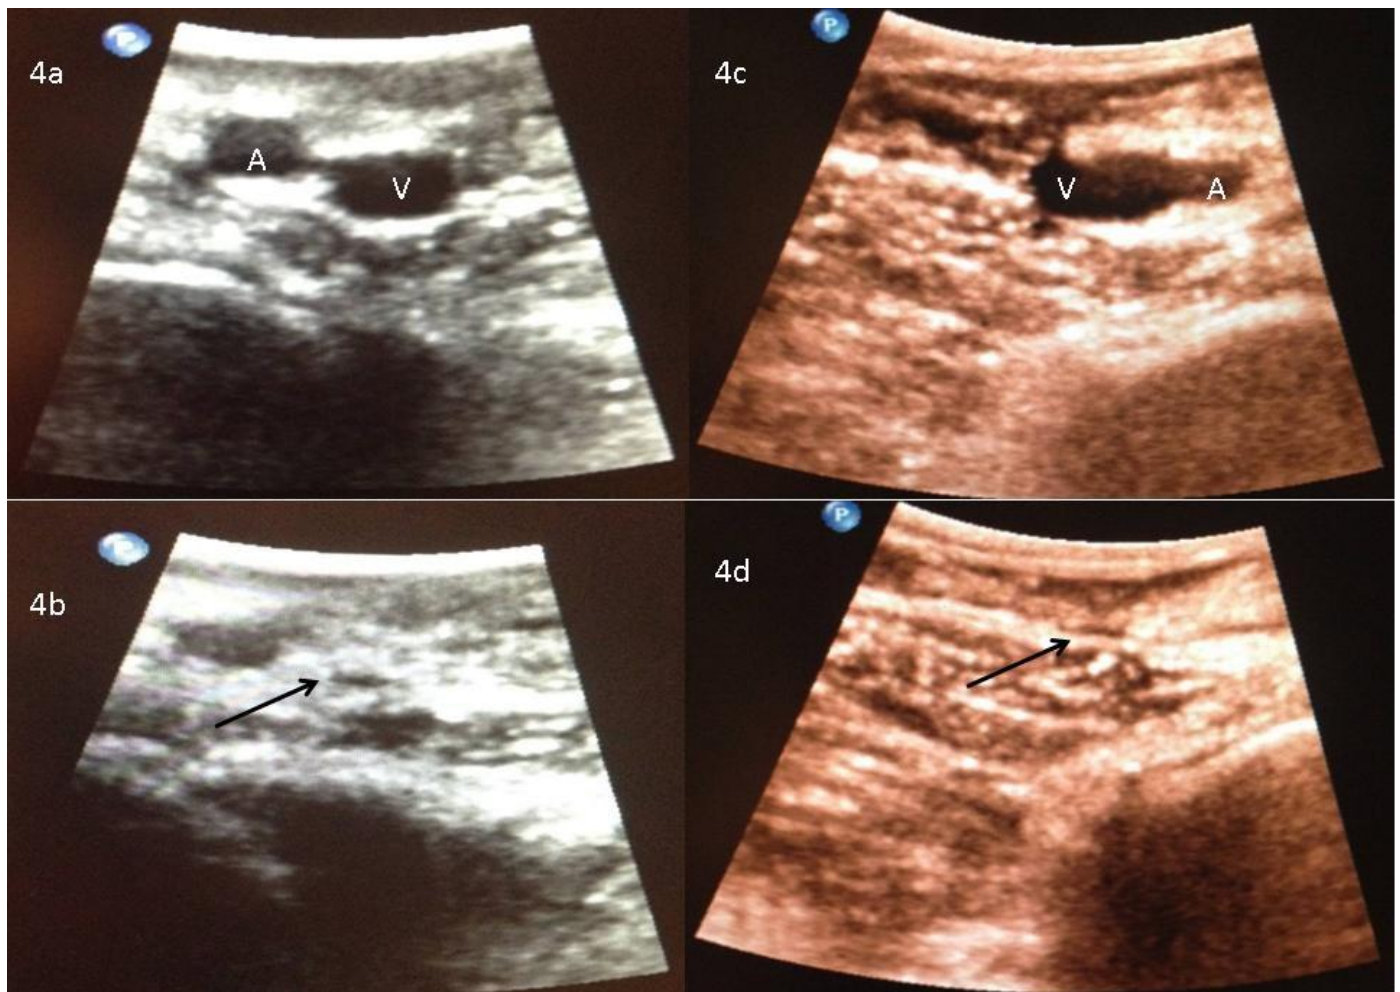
53-year-old female with a large leiomyoma with extension into the right gonadal vein and inferior vena cava. Findings: Transverse and longitudinal sonographic images of the bilateral lower extremities. 4a) Right common femoral artery (a) and vein (v) which appear patent without evidence of thrombus. 4b) Compression of the right common femoral vein (black arrow). No evidence of thrombus. 4c) Left common femoral artery (a) and vein (v) which appear patent without evidence of thrombus. 4d) Compression of the left common femoral vein (black arrow). TECHNIQUE: Longitudinal and transverse sonographic images of the bilateral lower extremities using a 5.0-13.0 MHz linear transducer.
